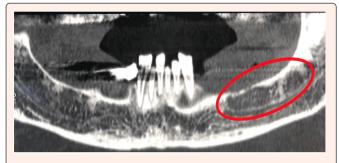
Pre-operative lower jaw CT show osteolytic area in corrispondace of III quadrant.
